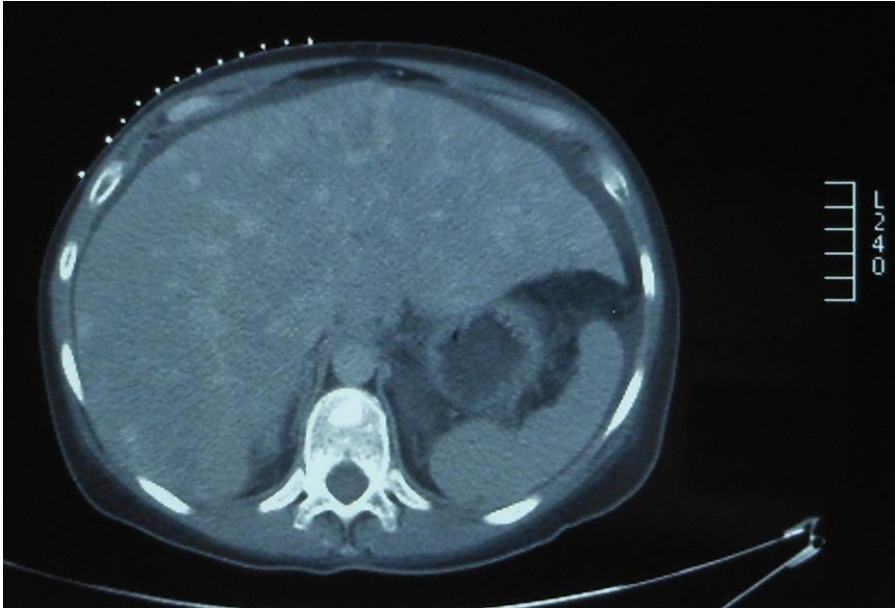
CT scan reveals a massive hepatomegaly due to diffuse metastasis.
